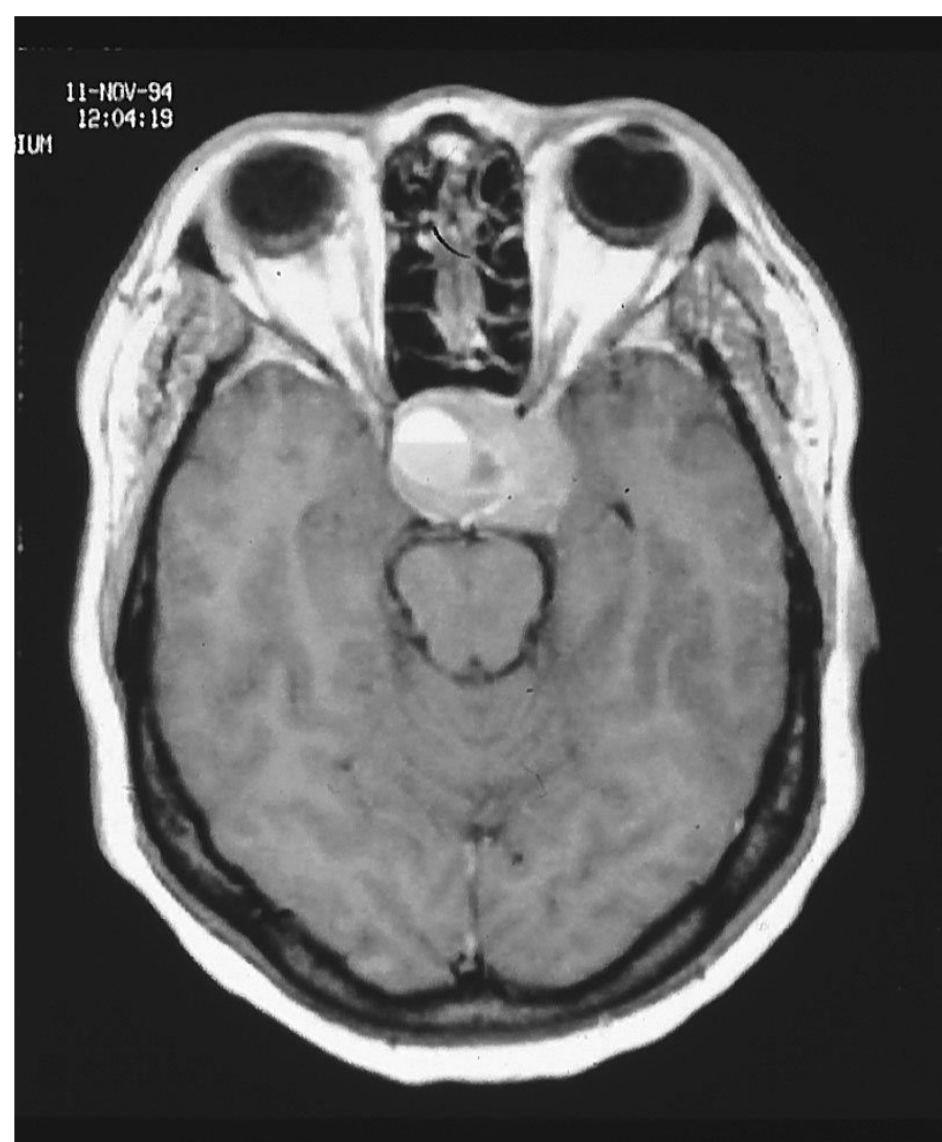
MRI revealed a large pituitary macroadenoma.
